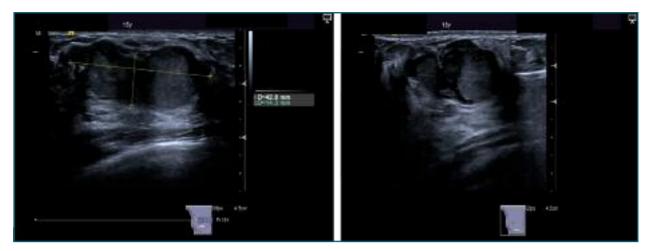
Ultrasound images of breast tubular adenoma, described as a mass with irregular borders, both echogenic and anechoic components, showing posterior acoustic enhancement.
